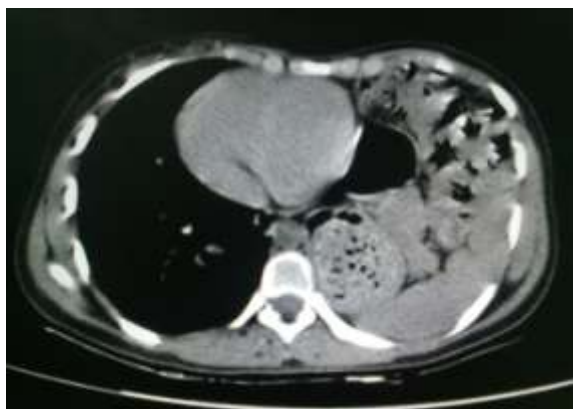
CT scan showing presence of stomach, spleen, gut in thorax
